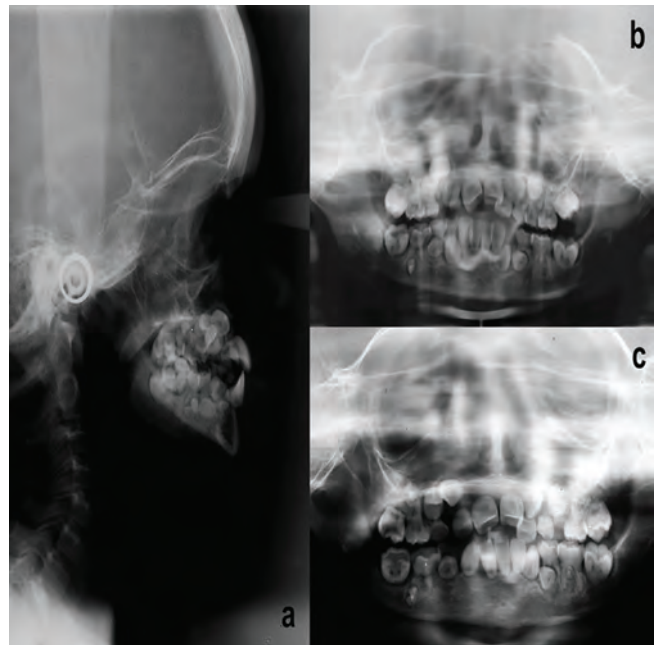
(a) Orthopantomographic radiographs showing over-retention of primary teeth, dental root shortening of all permanent teeth and retarded tooth development. (b) Lateral skull roentgenogram with cephalometric tracing shows mandibular and maxillary hypoplasia when the patient was 8 years old. (c) Present day orthopantomographic radiograph of the patient at 14 years old showing dental root shortening of all permanent teeth, retarded tooth development and tight space for the teeth in the arches.
